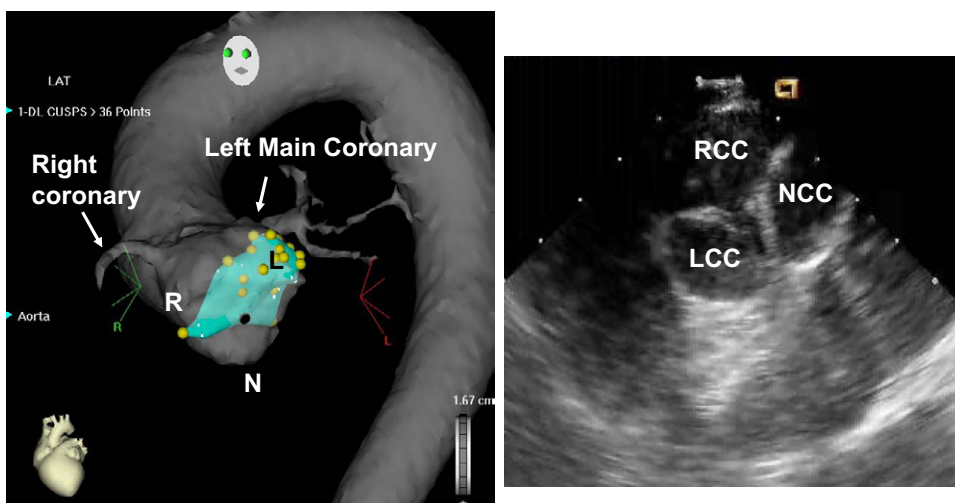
Left: CARTO merge figure showing detailed mapping of the aortic cusp region and the typical anatomic locations of each valve relative to the coronary arteries. (L = left coronary cusp; N = noncoronary cusp; R = right coronary cusp). Right: Corresponding intracardiac echocardiographic image depicting the three cusps of the aortic valve. LCC = left coronary cusp; NCC = noncoronary cusp; RCC = right coronary cusp.
